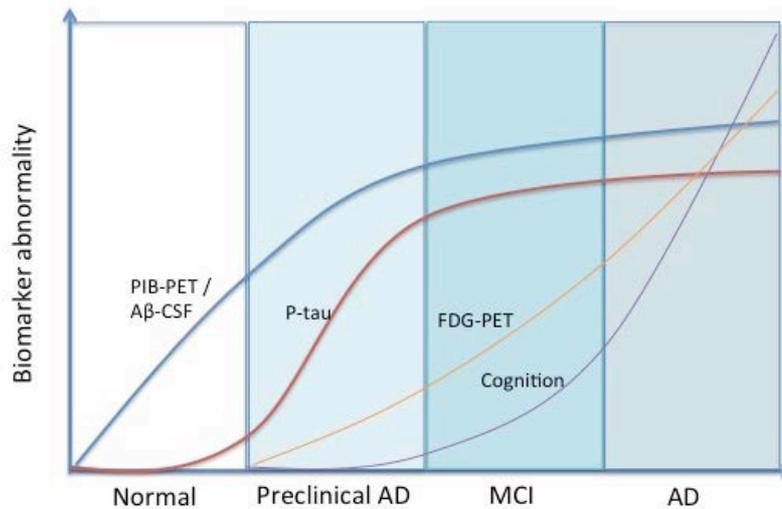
Temporal changes of biomarkers in preclinical Alzheimer's Disease (AD), mild cognitive impairment (MCI), and AD (Jack and Holtzman, 2013; Jack et al., 2010; Nordberg et al., 2010). Abbreviations: FDG – fluoro-deoxy-D-glucose, PET – positron emission tomography, PIB – Pittsburgh compound B.
